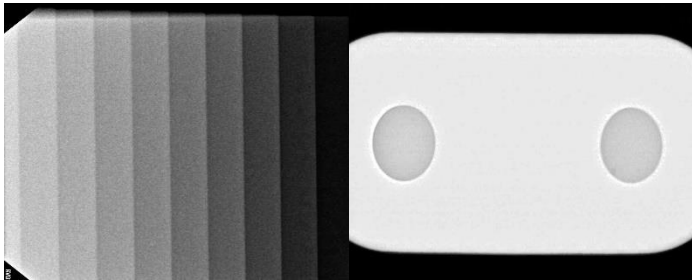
Radiograph of sealer and Aluminum step wedge
